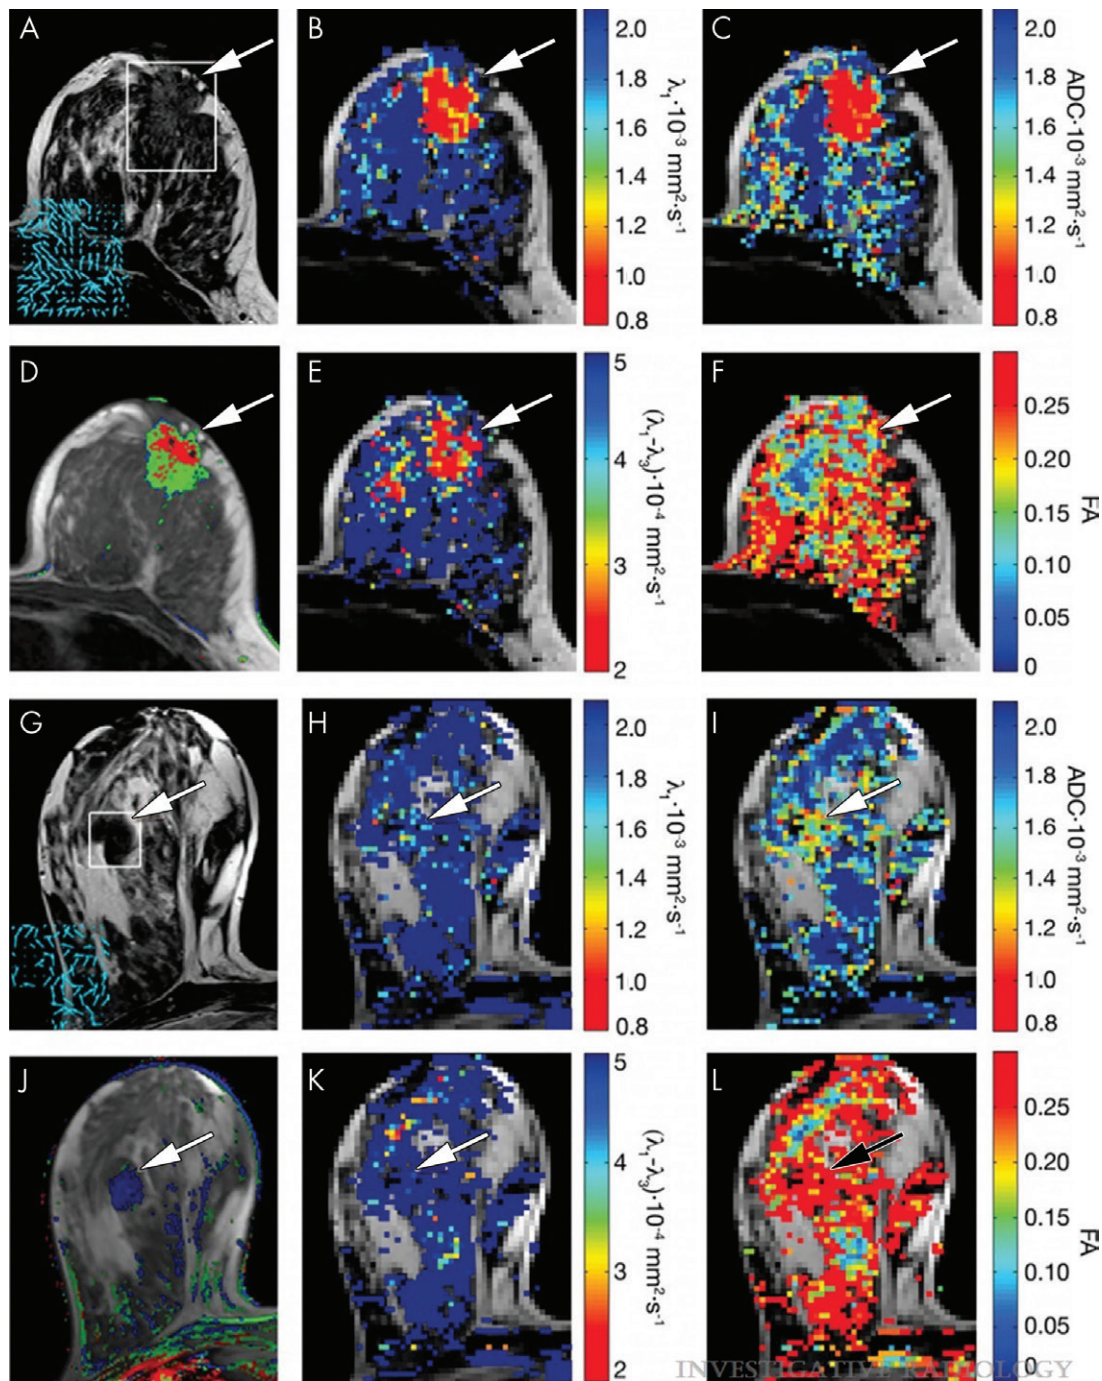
Parametric diffusion maps of breast lesions. Lesions are indicated by arrows. The color-coded maps overlaid on the T2 image were processed with software (Matlab version 7.0.1; Mathworks, Natick, Mass). *A–F*, Invasive ductal carcinoma (37 mm, grade 2) and *G–L*, fibroadenoma (20 mm). *A, G*, T2-weighted images of section at the center of the lesion showing anatomic features. Insert shows a vector map of v_1 of the region marked by white square on the T2-weighted image. *B, H*, λ_1 maps of the same section as in *A* and *G*, respectively, overlaid on the corresponding T2-weighted image. *C, I*, Apparent diffusion coefficient (ADC) maps of the same section as in *A* and *G*, respectively, overlaid on the corresponding T2-weighted image. *D, J*, Color-coded parametric maps of dynamic contrast-enhanced MRI analysis (three-time-point method) of the same section as in *A* and *G*, respectively, overlaid on a T1-weighted image, show the color-coded contrast-enhanced region. The red pixels in the lesion indicate fast wash-in and fast wash-out, and the green pixels show fast wash-in followed by a plateau; both reflect cancer vascular properties. The blue pixels in the benign lesion indicate a delayed wash-out. *E, K*, $\lambda_1 - \lambda_3$ map of the same section as in *A* and *G*, respectively, overlaid on the T2-weighted image. *F, L*, Fractional anisotropy maps of the same section as *A* and *G*, respectively, overlaid on the T2-weighted image. Reprinted, with permission, from reference 5.
